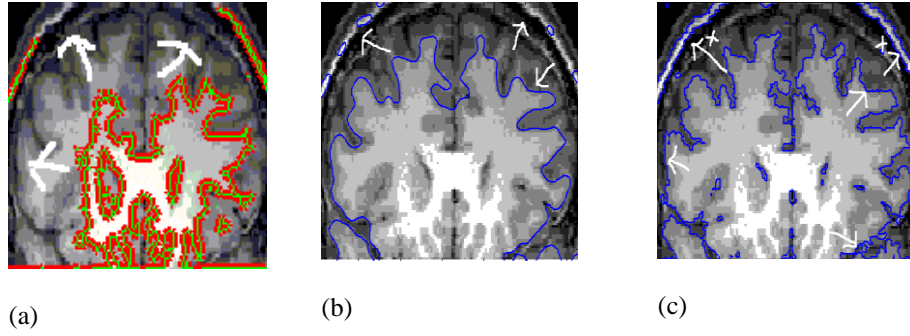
Segmentation of a second CT scan image of a brain that focus on the white flare. The final results using the C-V, SGLACM, and proposed methods are shown in the first, second, and third columns when $\alpha=0.077$ and $\sigma = 1.0$, respectively.
